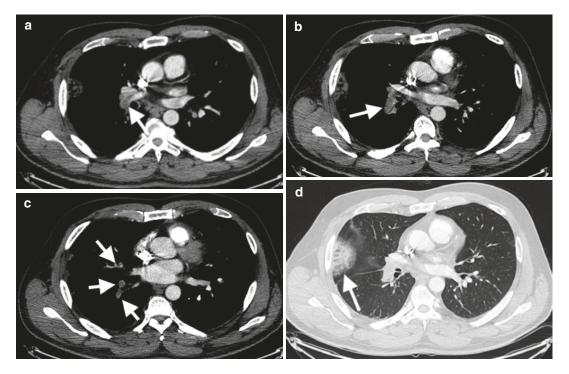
Acute pulmonary embolism in a 28-year-old female with antiphospholipid syndrome. (a, b, c) Axial arterial phase-enhanced CT with acute filling defects
